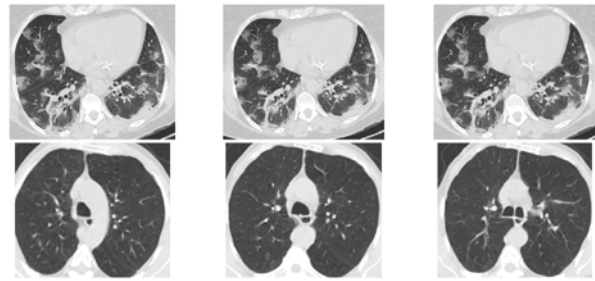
A sample of a CT scan from the SARSCoV2 dataset.
